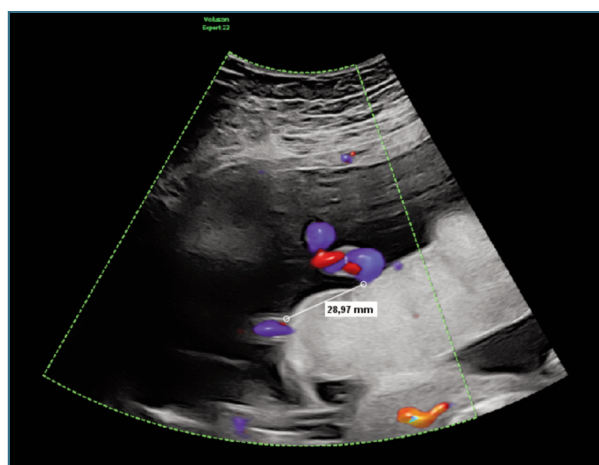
Ultrasound view showing two cord insertions in the placenta separated by approximately 29 mm, indicating proximate umbilical cord insertion.
